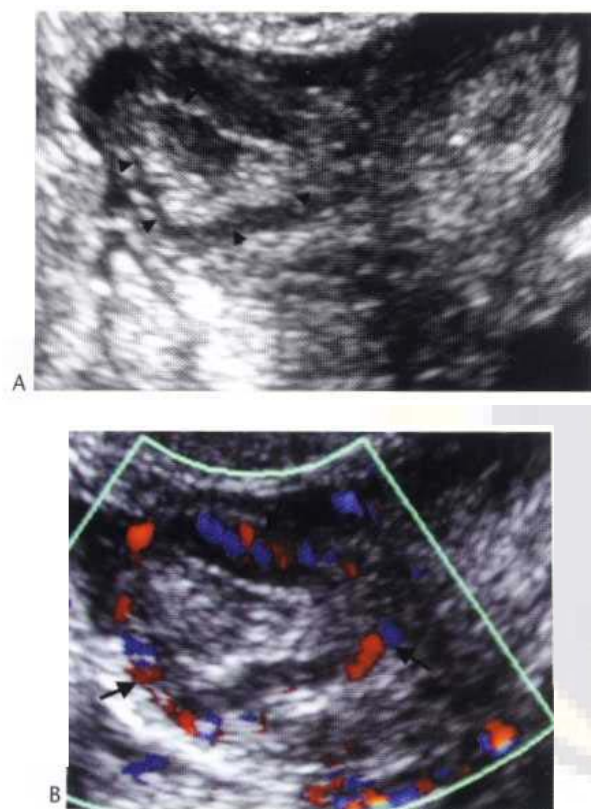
(A) EVS. Irregularly shaped echogenic cyst (arrowheads) due to a collapsing corpus luteum. (B) Colour Doppler. Flow around the corpus luteum (arrows) due to neovascularisation.
